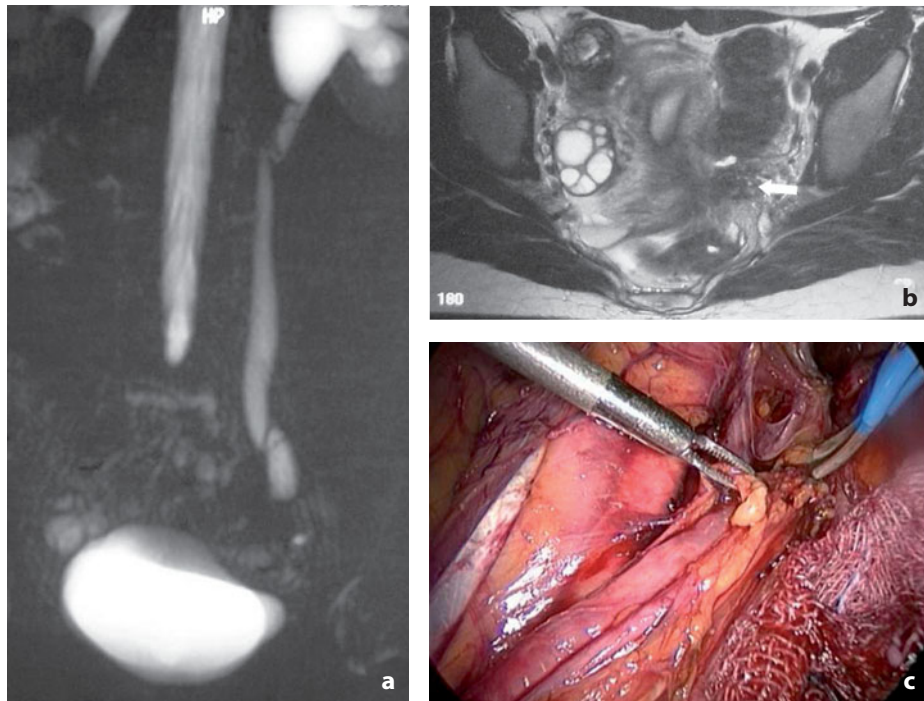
Magnetic resonance. Ureteric endometriosis. a MR urography shows the dilatation of the left pelvis and ureter. b T2-weighted sequence shows the distal segment of the ureter surrounded by a solid mass (*arrow*) with irregular margins and low signal intensity. Laparoscopy (c) confirms the distal ureteric obstruction as a solid endometrial plaque
